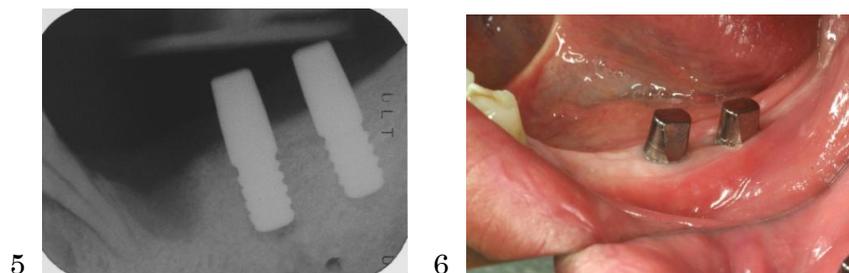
Dental radiograph appearance at the time when placing 5MS implants to the No. 29 and 30 positions (05.25.2005). A partial denture was fitted onto the No. 10 to 15 implants after sufficient elevation of the bone.
